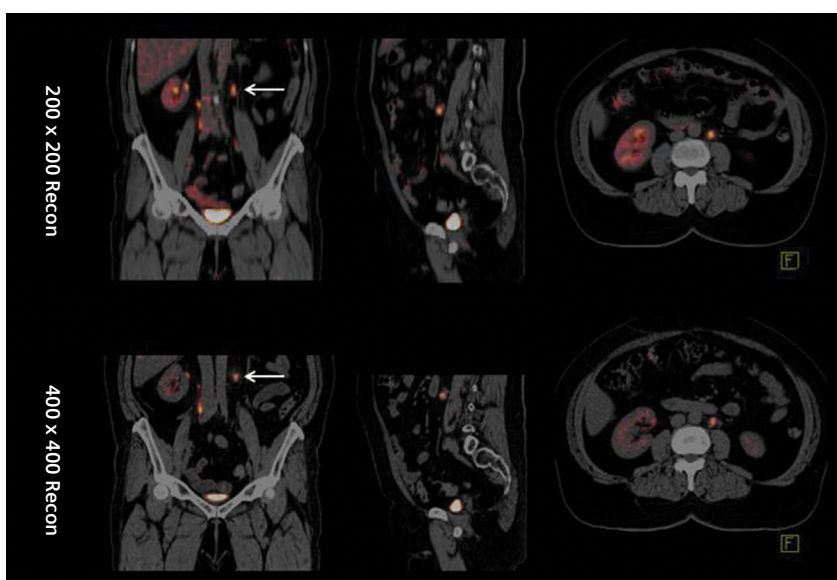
Fused PET/CT images show sharper delineation of left para-aortic lymph node metastases with Hi-Res reconstruction.
